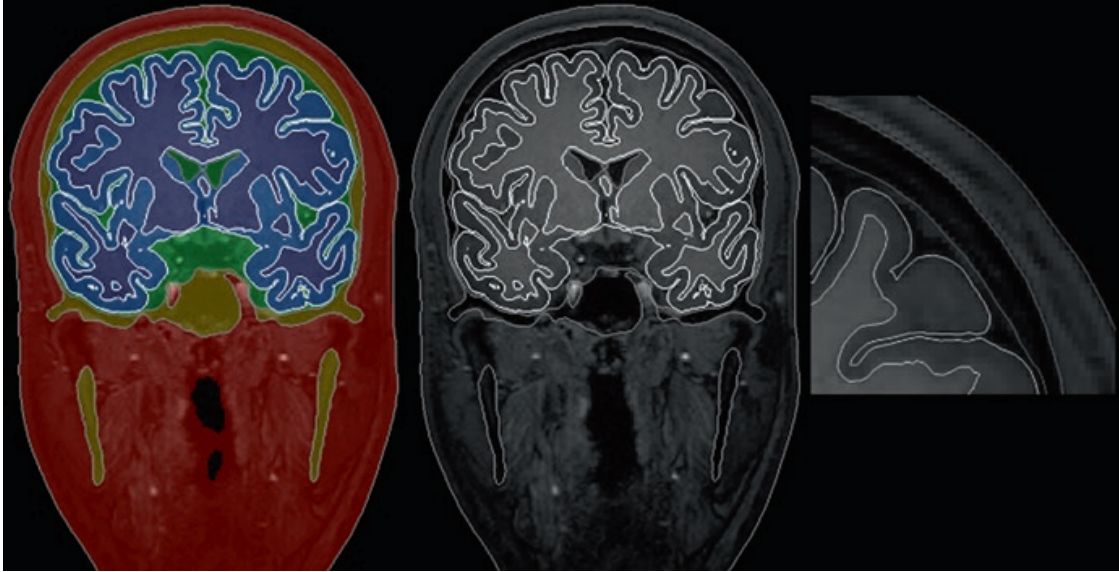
Data displayed after calling the check option. Left: T1-weighted scan with the segmentation and structure borders overlaid. Middle: structure borders overlaid on the T1-weighted scan after de-selecting the segmentation in freeview. Right: zoom-in of the cortex. Note that the segmentation borders nicely follow the intensity borders between the tissues
